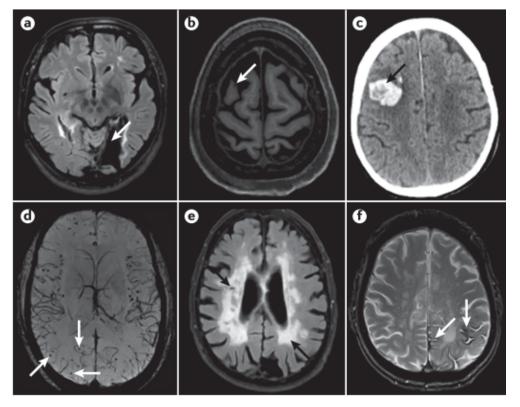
MRI manifestations of cerebrovascular disease leading to VCI symptomology. (A) Large vessel infarct detected using fluid-attenuated inversion recovery (FLAIR) sequences (B) Microinfarct detected using T1-weighted MRI (C) Macroscopic Haemorrhage detected using CT (D) Multiple microbleeds indicative of cerebral amyloid angiopathy detected using susceptibility- weighted imaging (E) Extensive white matter hyperintensities (WMHs) detected using FLAIR sequences (arrows point to WMHs). (F) Superficial siderosis detected using susceptibility weighted imaging. Figure from van der Flier, et al., 2017.
